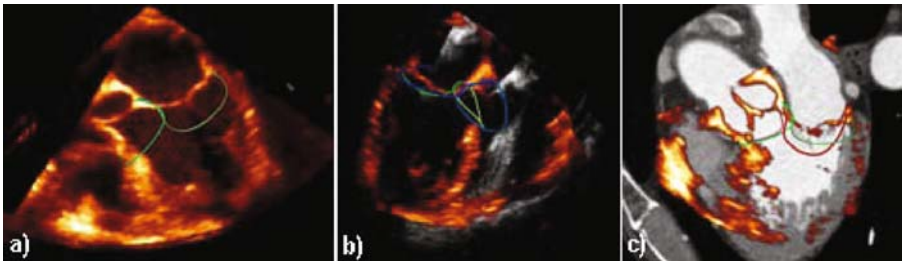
a) Patient heart instance at Stage₁ acquired using tracked US and showing the valve annuli; b) Stage₁ (orange) and Stage₂ (gray) instances of the heart showing relative heart displacement and corresponding segmented valvular structures; c) Initial peri-operative US instance (Stage₁) registered to the pre-operative dataset and displayed within the CT coordinate space.
